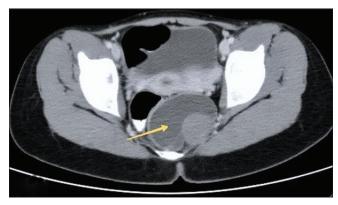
Axial section of contrast-enhanced computed tomography scan of abdomen and pelvis showing a large well defined nonenhancing soft-tissue density cystic component lesion (shown by yellow arrowhead) in the presacral and precoccygeal space, displacing rectum to the right
